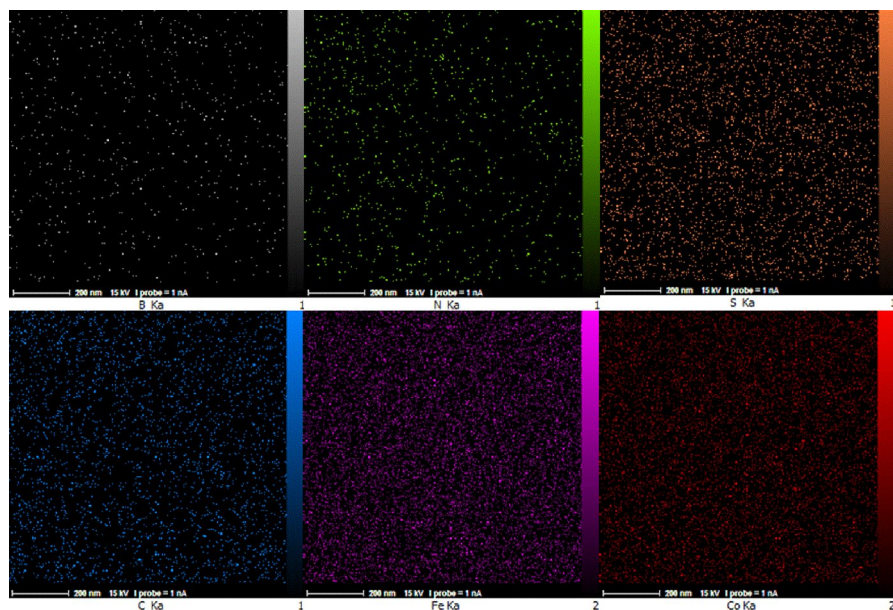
The X-ray mapping of CoFe_2O_4 @TRIS@sulfated boric acid MNPs
